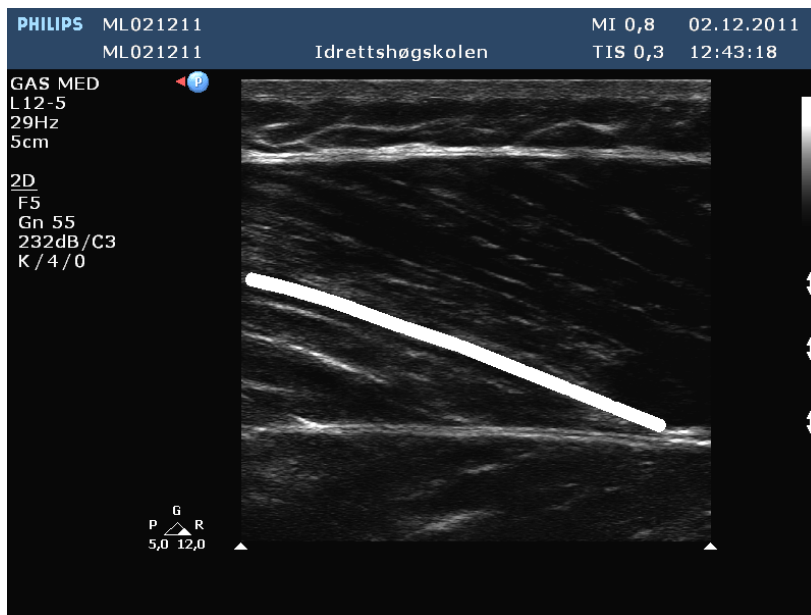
B-mode ultrasound image of the vastus lateralis muscle, with a fascicle marked.
